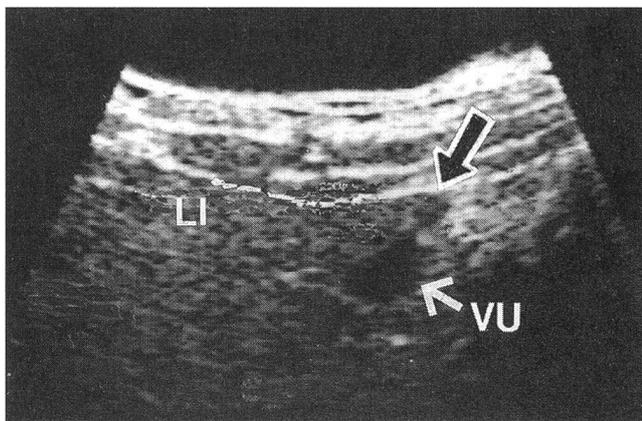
Ultrasonographic cross section through the umbilical vein (VU) of a newborn calf at the level of the caudoventral margin of the liver (Position 7; see figure 2). The arrow indicates the apex of the caudoventral lobe of the liver (LI) which lies adjacent to the abdominal wall.
